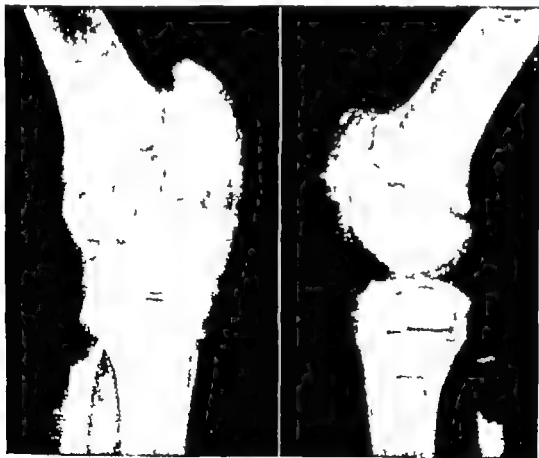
(Left) Observe the advanced fragmentation of the patella and the distention of the capsule. Case M. V. male, 9 years old, osteomyelitis of the patella. (Right) Roentgenograms of same case 6 months postoperatively. Two years later the range of motion was from 70° to 180° .
